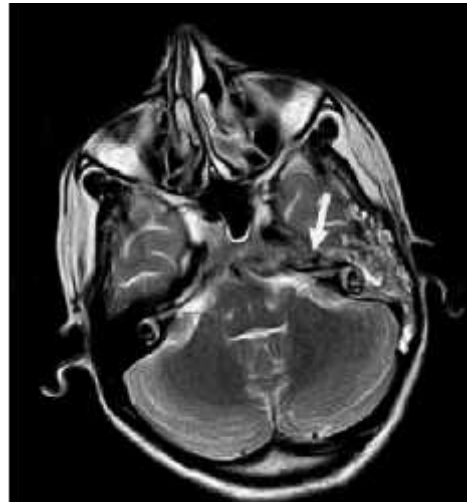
MRI-AXIAL T2 weighted image shows left otomastoiditis with iso to hyper intense collection in petrous part of left temporal bone, left prepontine cistern and middle ear (arrow).
